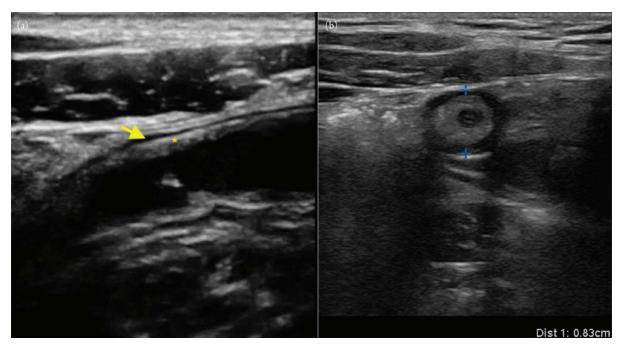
(a) Ultrasound findings of acute appendicitis. This longitudinal image of acute appendicitis demonstrates a diameter >6 mm, thickening of the bowel wall (*), and periappendiceal fluid (arrow). (b) Ultrasound findings of acute appendicitis. This transverse image of acute appendicitis demonstrates a diameter >6 mm with a target sign.
